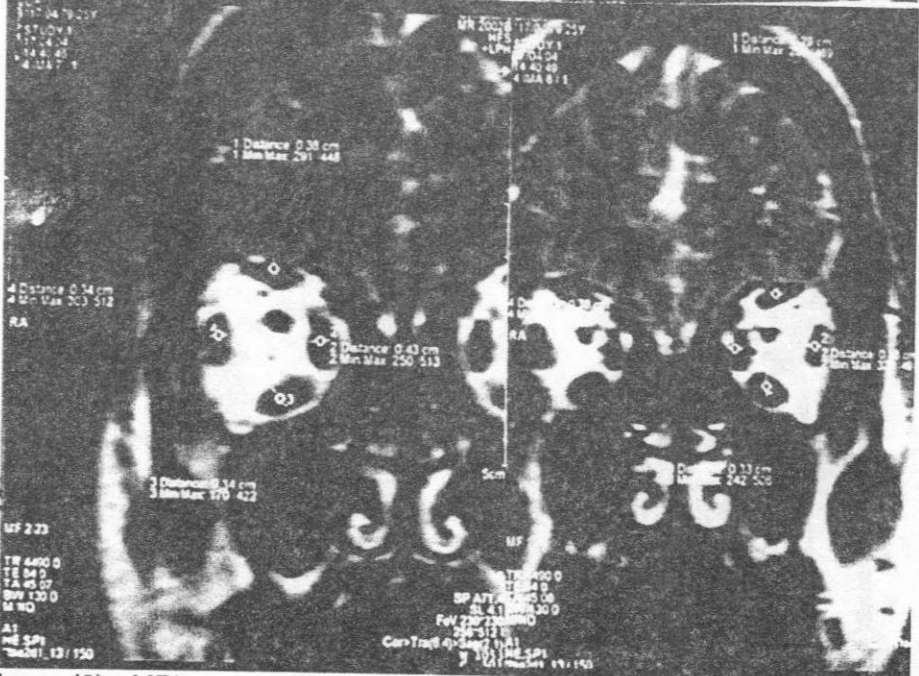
MRI scan of clinically evident enlargement of the extraocular muscles before surgery (A) and their reduction in thickness 6 month postoperatively .
